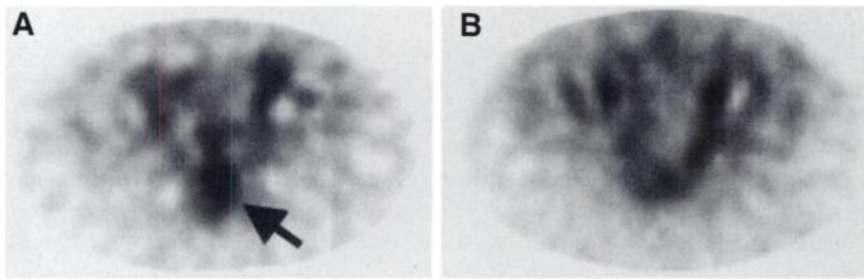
SPECT arcitumomab images of patient with rectal cancer. (A) Coronal image shows intense increased uptake in posterior pelvis (arrow). (B) Corresponding image obtained 6 mo later after low anterior resection.
